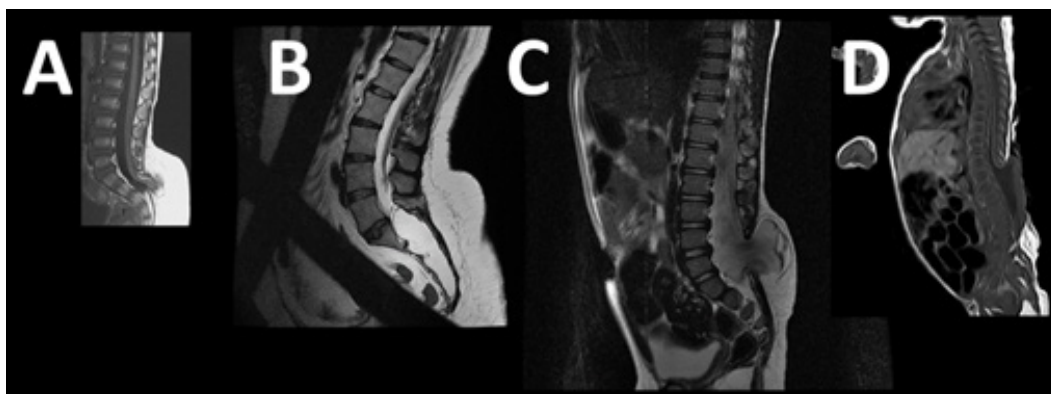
MRI sections show lipomeningocele, meningocele, myelomeningocele, or myelocystocele respectively.
